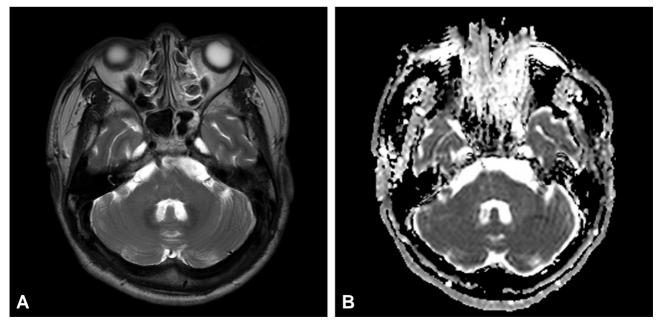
A cranial T2-weight (A) and gradient- echo (B) MRI showing no abnormal finding
